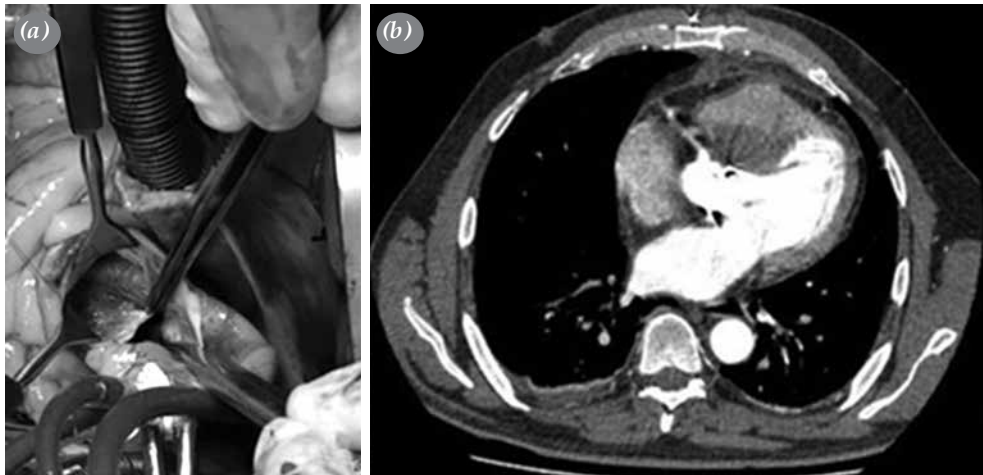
(a) Intraoperative image of aneurysm and (b) postoperative image of control computed tomographic angiography.
